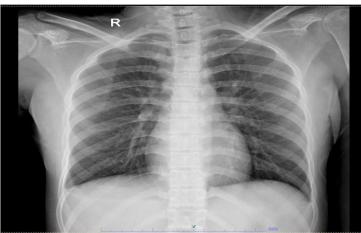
Chest X-ray in anteroposterior (AP) projection on January 20, 2025
